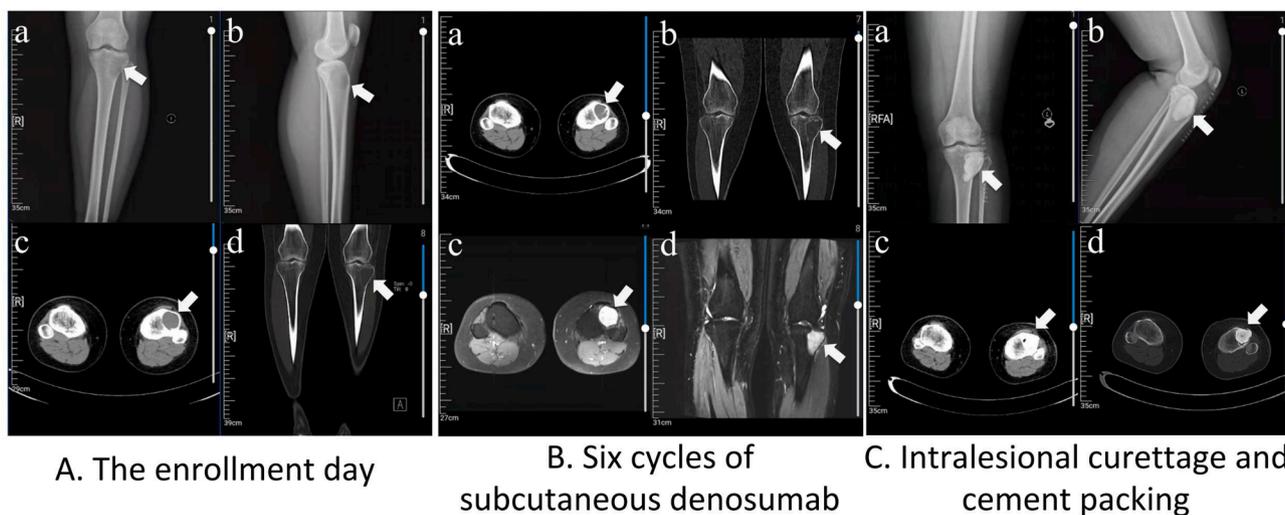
Radiography and CT scan (Fig. 4A) revealed an expansive Campanacci grade II osteolytic lesion. Radiography and MRI revealed tumor shrinkage and osteosclerosis of the margins (Fig. 4B) after six cycles of denosumab. The lesion was filled with bone cement to restore the support of the lateral tibial plateau (Fig. 4C).
